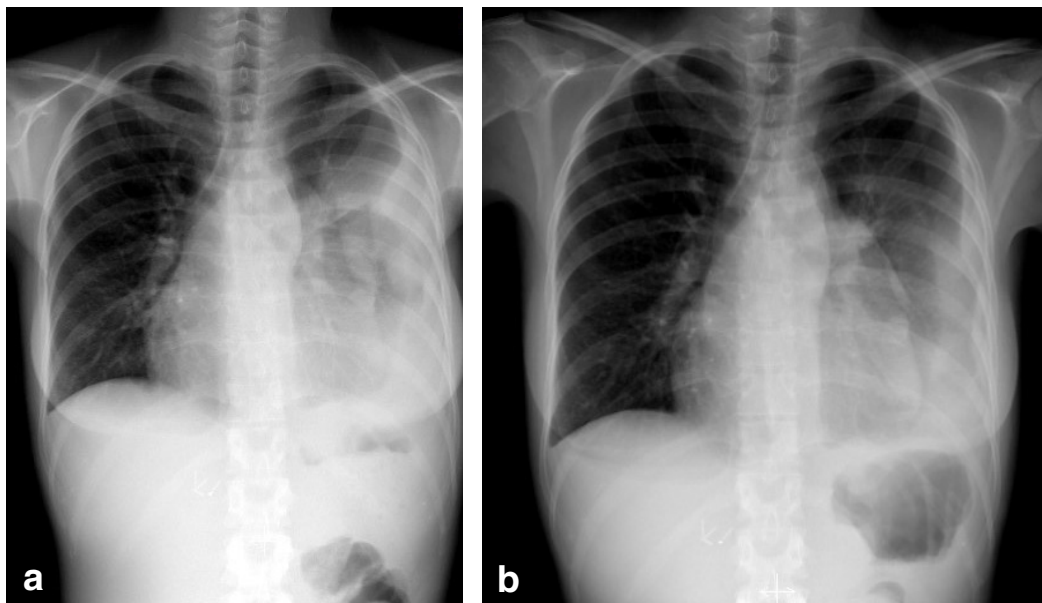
Chest x-ray showing large left-sided PE at a) one month and b) one week before FXIII treatment.
